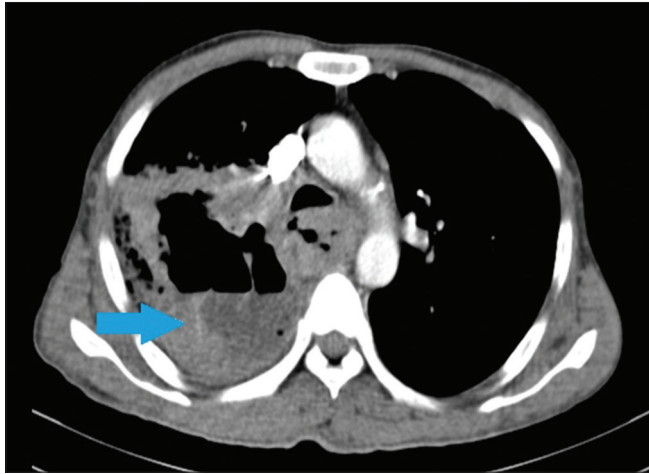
Axial contrast-enhanced (intravenous) multi-detector computed tomography scan image of thorax showing thick walled cavity with air-fluid level in the right upper lobe (arrow)
